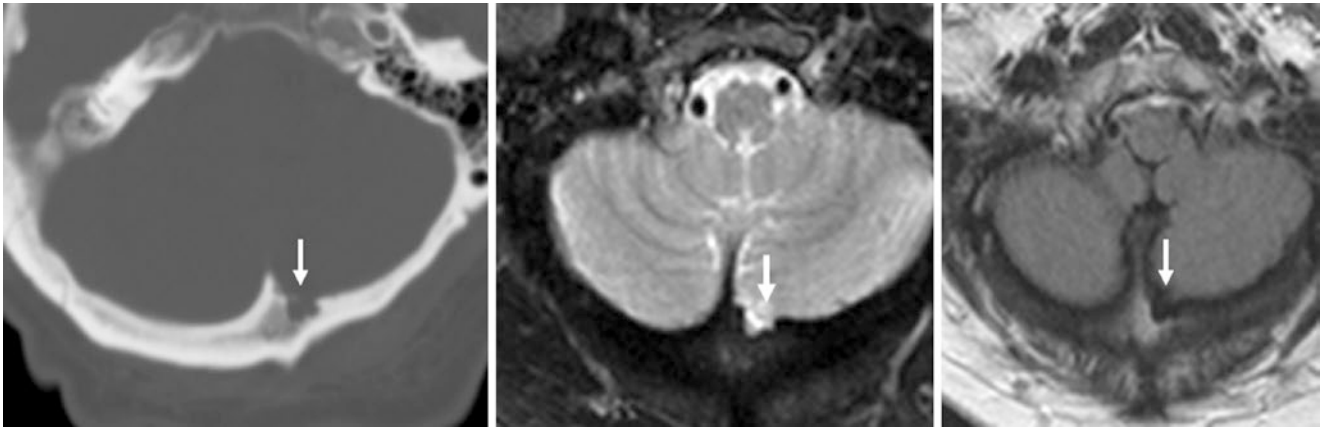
A 60 year old with a small pacchionian granulation that appears lobulated on NECT (*left*), axial T2WI (*middle*), and postcontrast FLAIR MRI (*right*). Note the suppression of the CSF signal on FLAIR and the lack of any associated enhancement (*right*)
